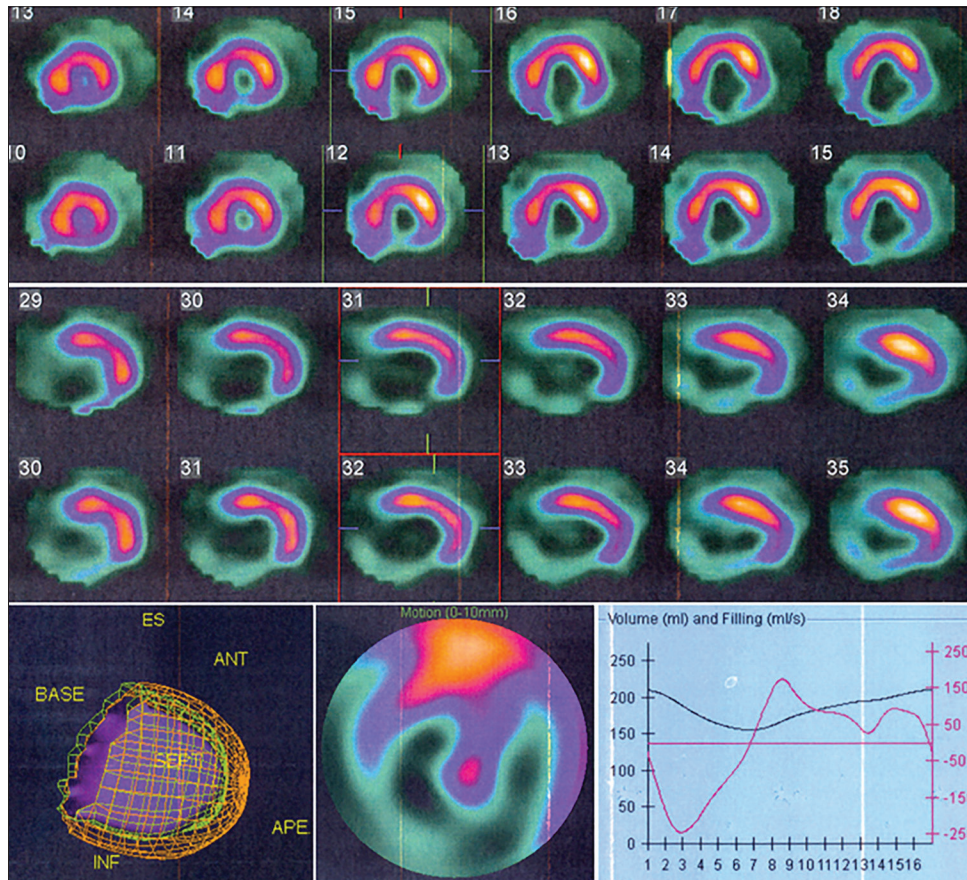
The tomographic slices of myocardial perfusion SPECT imaging in stress and rest phases (upper and middle panels) and the results of gated study (lower panel) as three-dimensional display, polar plot of motion and time-volume curve
